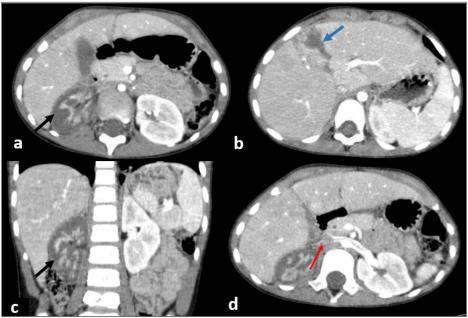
Follow-up abdominal CT angiography demonstrating:
